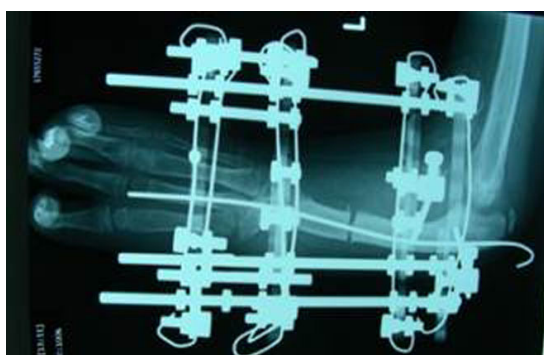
X-ray of centralization and lengthening of forearm. K-wire was removed at 2 mos.
